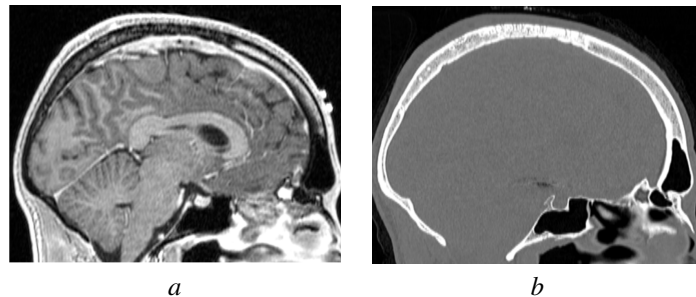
A sagittal view of a human brain acquired using (a) T1-weighted MRI and (b) CT
